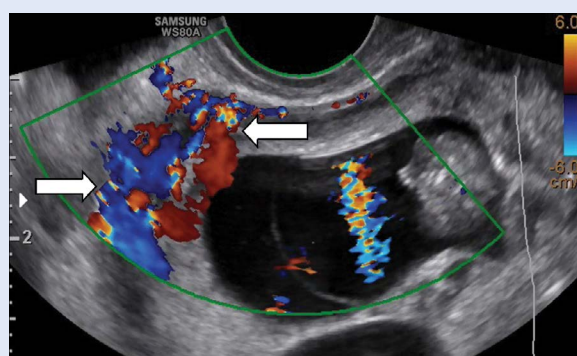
After two weeks thinning of the myometrium in the anterior uterine wall was seen on transvaginal ultrasound and there was a suspicion of bladder infiltration.
